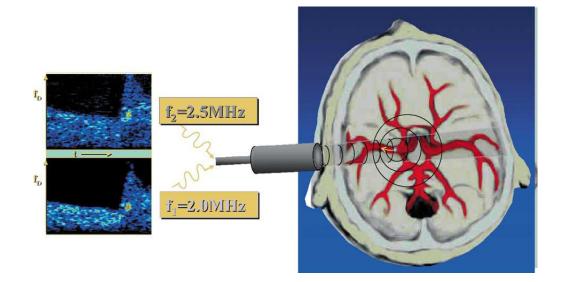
Multifrequency Doppler with insonation of the middle cerebral arteries using 2.0 and 2.5 MHz frequencies. From Russel, 2002
